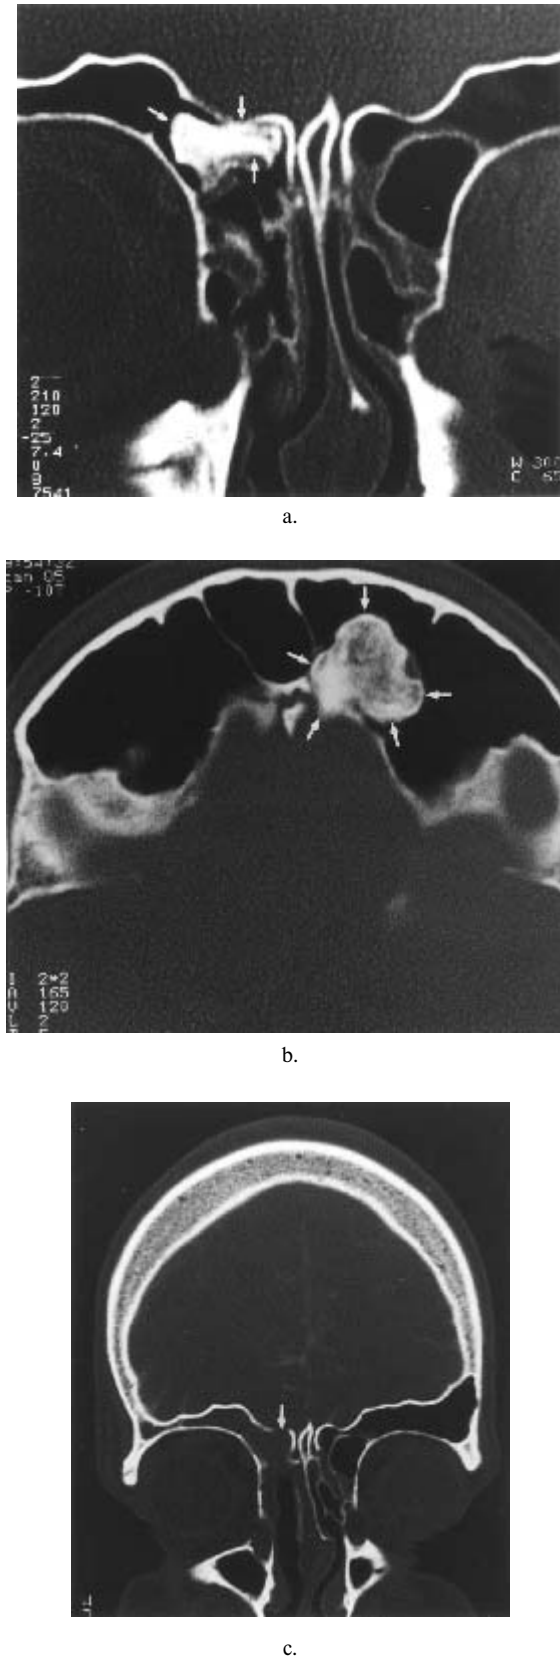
a-c. Frontal sinus osteoma in a 40-years-old male patient originating from the inferior posterior frontal sinus wall (a, arrow) and located medial to a virtual sagittal plane through the lamina papyracea (b). Endonasal osteoma removal was performed. Postsurgical computed tomography (c) indicates complete endonasal tumour resection.
